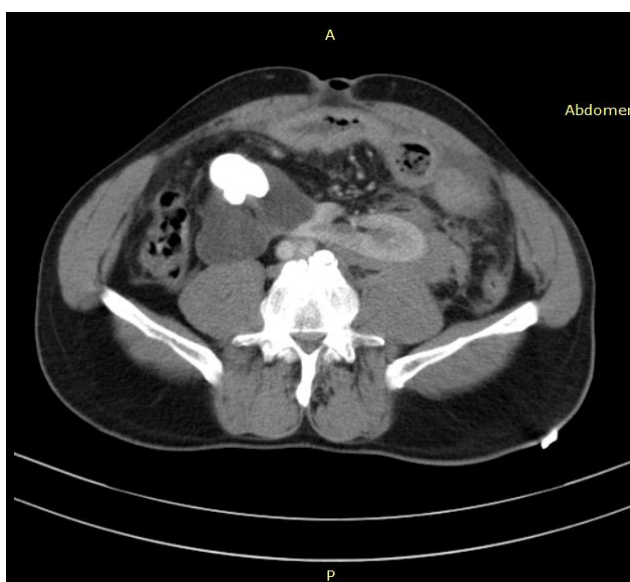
Axial CT post contrast image at the lower isthmic level showing dilated pelvicalyceal system of the lower moiety with staghorn calculus on the left side and normally enhancing parenchyma on the right side.
